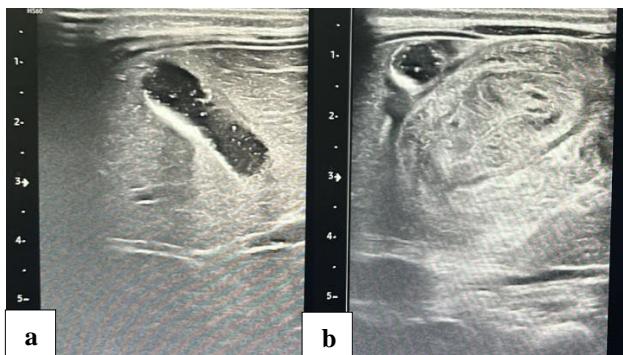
(a and b): Ultrasonography image revealing residual ileocolic intussusception with mild peritonitis in the epigastric and right lumbar regions.
